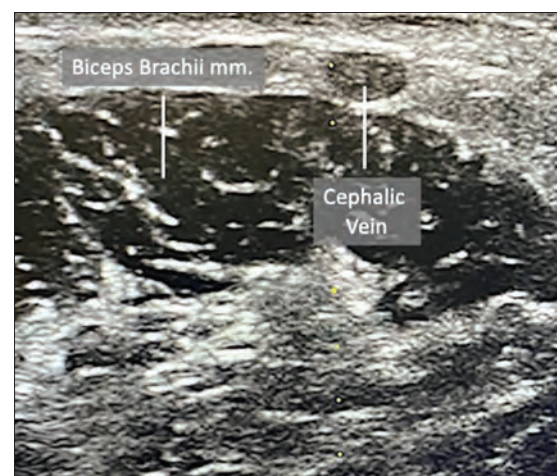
Transverse ultrasound view of the cephalic vein of the upper arm.
